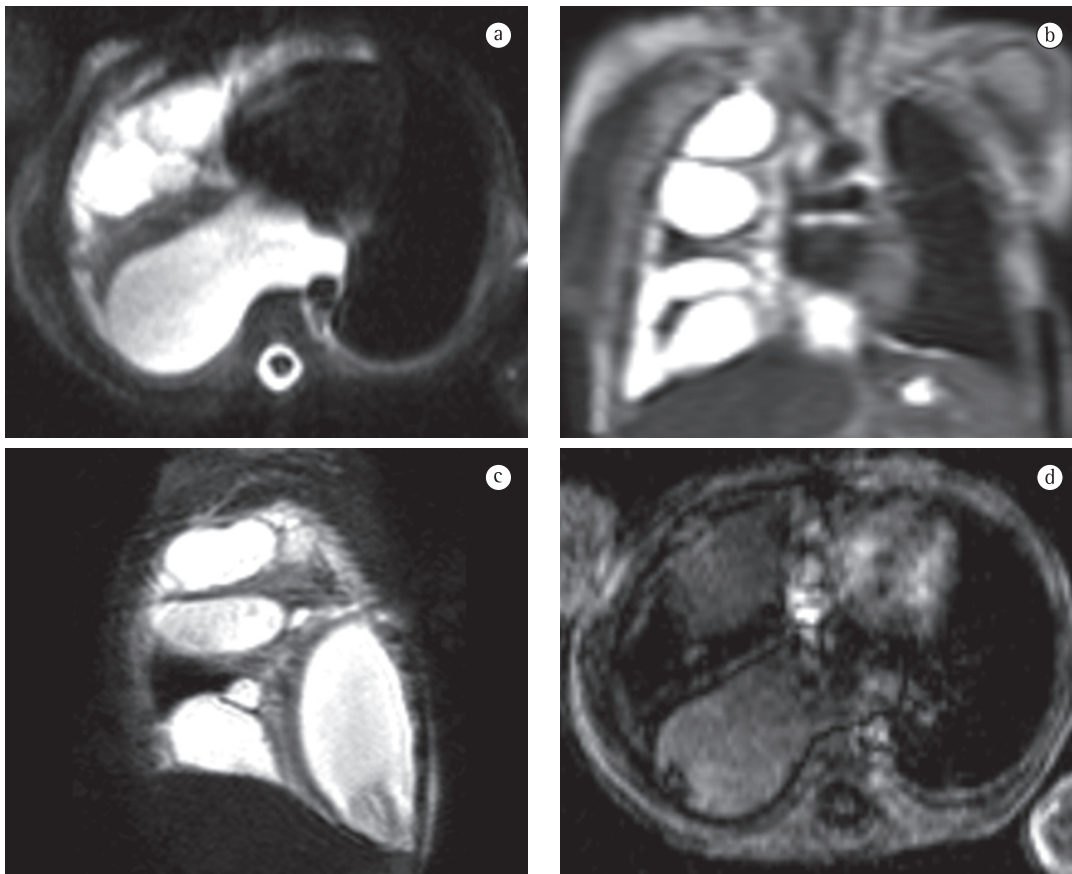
Magnetic resonance images showing chylothorax in an infant with recurrent pleural effusions since birth. Pleural fluid analysis showed the presence of lymph. Axial T2-weighted image (a), coronal T2-weighted image (b), and sagittal T2-weighted image (c) show complex, loculated pleural effusion with pockets delimited by irregular septations and atelectasis of the adjacent lung parenchyma. Axial T1-weighted image (d) shows the slightly higher signal intensity of the pleural fluid due to the greater protein content of the lymphatic effusion.
